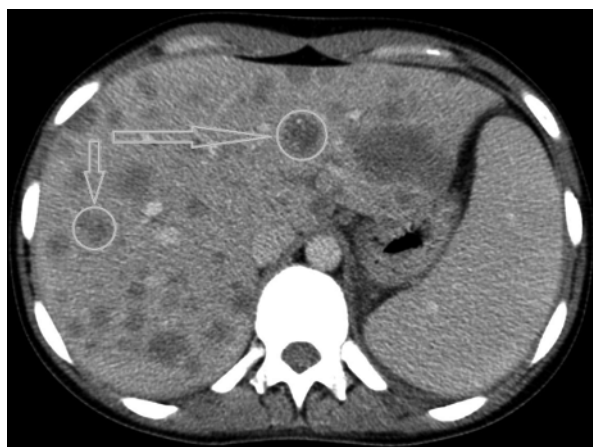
CT scan of the abdominal cavity. Enlargement of the liver and spleen. Numerous centres of reduced density in the whole liver
